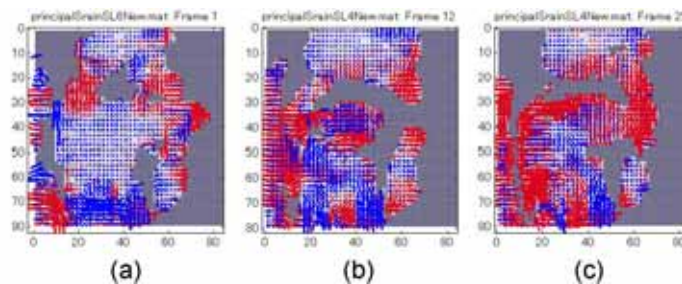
The principal strain pattern obtained using the HARP MRI analysis method. The frames are the same as those in Fig. 3.
